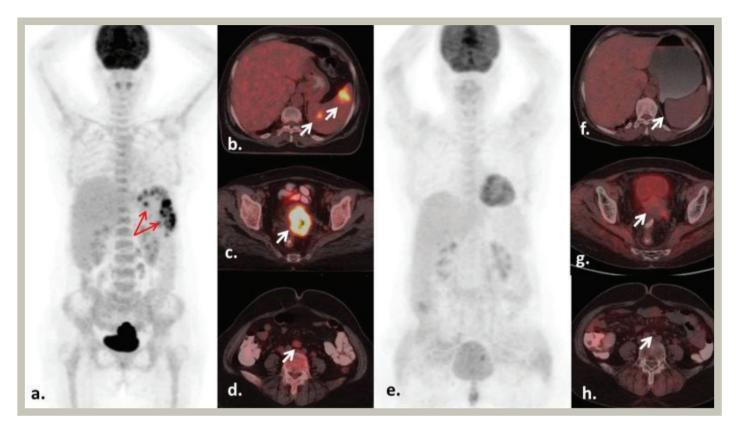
Pretreatment FDG-PET/CT images. a) MIP image showing multiple hypermetabolic spleen lesions. b) Fusion axial PET/CT image showing hypermetabolic primary uterine cervix carcinoma. d) Fusion axial PET/CT image showing slightly hypermetabolic paraaortic metastatic lymph node. FDG-PET/CT images three months after radiation therapy. e) MIP image showing no abnormal FDG uptake in the spleen. f) Fusion axial PET/CT image showing total regression of hypermetabolic splenic lesions. g) Fusion axial PET/CT image showing slightly hypermetabolic and anatomical regression of mildly hypermetabolic paraaortic metastatic lymph node.
